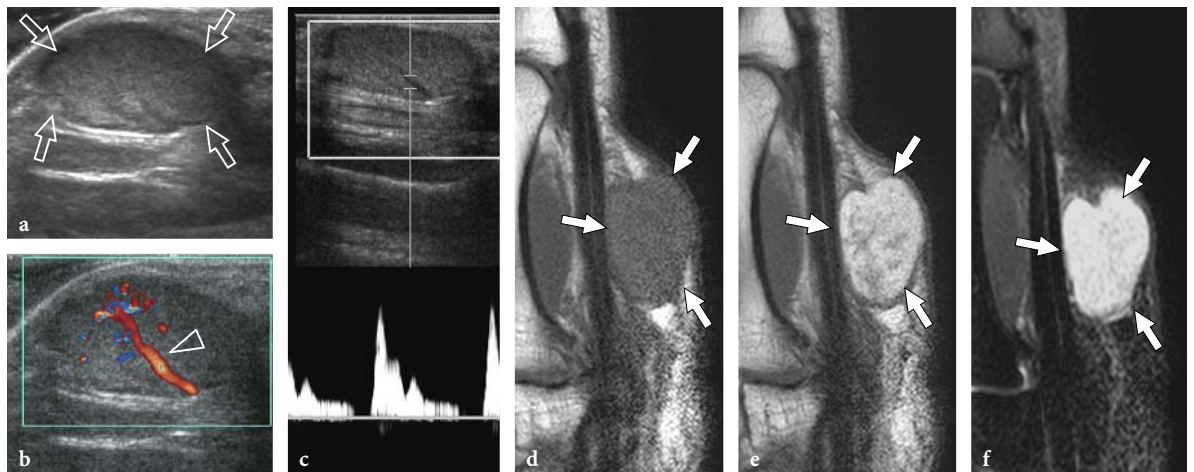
Angioliomyoma. a,b Sagittal a gray-scale and b color Doppler US images of the palm demonstrates a subcutaneous sharply delineated solid hypoechoic mass (*arrows*) with a large arterial pedicle branching within (*arrowhead*). c Spectral Doppler analysis of intratumoral vessels shows high-resistance arterial waveforms. d–f Sagittal d T1-weighted, e postcontrast T1-weighted and f fat-suppressed T2-weighted MR imaging correlation reveal a predominantly hyperintense mass (*arrows*) in T2-signal intensity and after gadolinium administration. In the postcontrast image, small hypointense foci are visible within the tumor
